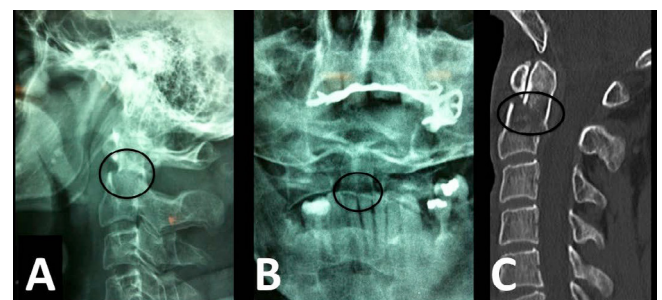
(A) Lateral cervical spine radiograph demonstrating a Type II odontoid fracture. (B) The fracture seen with an open mouth view. (C) Sagittal cervical spine CT scan with < 6 mm of dens displacement.
